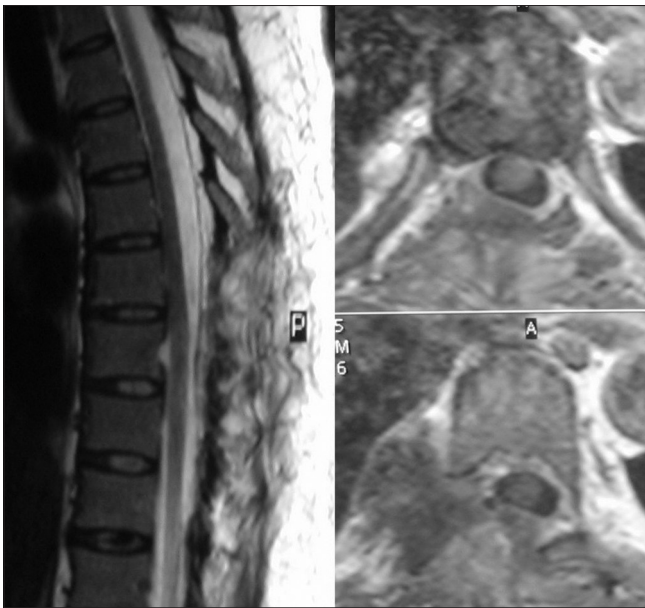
Postoperative MRI: the total mass removal corresponded to a good dural sac re-expansion.
